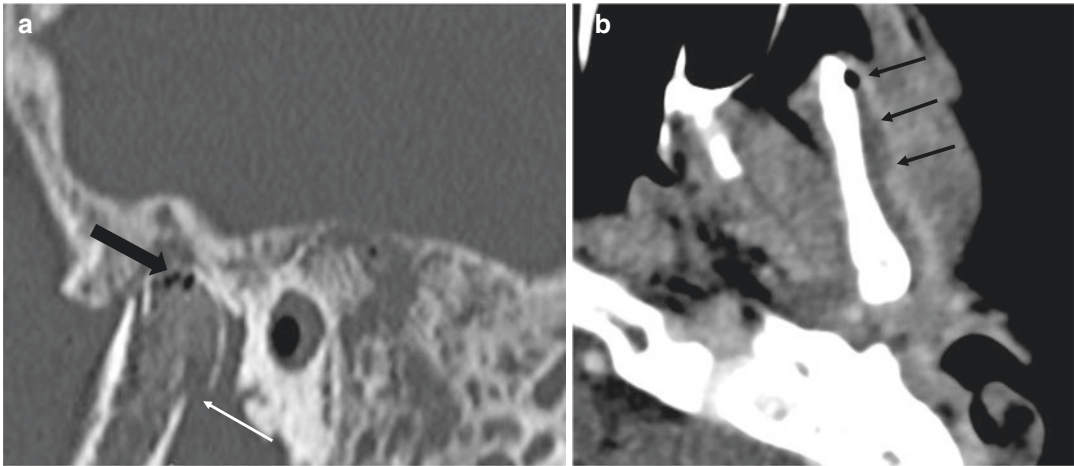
(a) Sagittal CT bone window showing a left mandibular condyle fracture (white arrow) and gas locules in the medullary cavity (thick black arrow). (b) Axial CECT soft tissue window showing a rim enhancing
